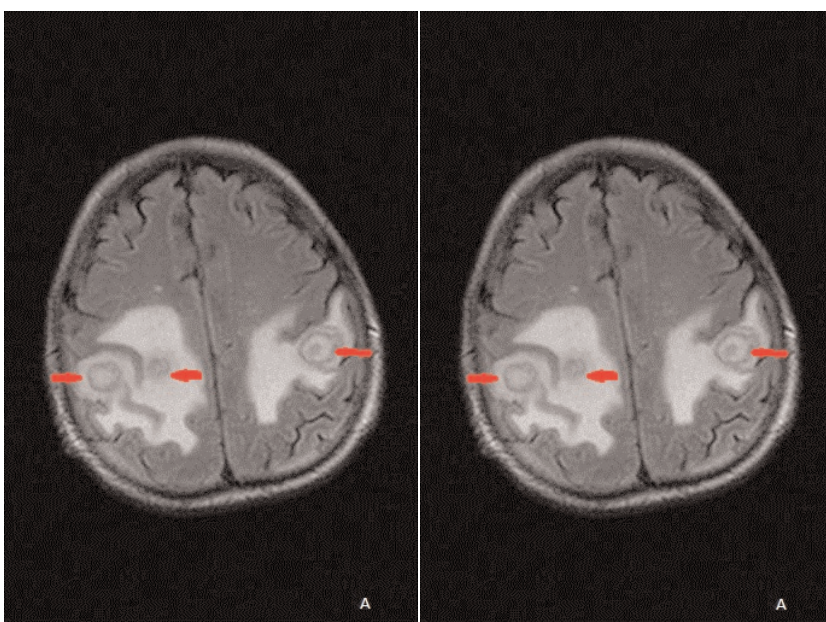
Brain MRI, A-Fluid Attenuation Inversion Recovery (FLAIR) sequence; B-post contrast T1 Weighted Image (WI), revealed multiple focal lesions with post contrast ring enhancement (arrows) and surrounding edema; consistent with abscesses in parietal lobes bilaterally
